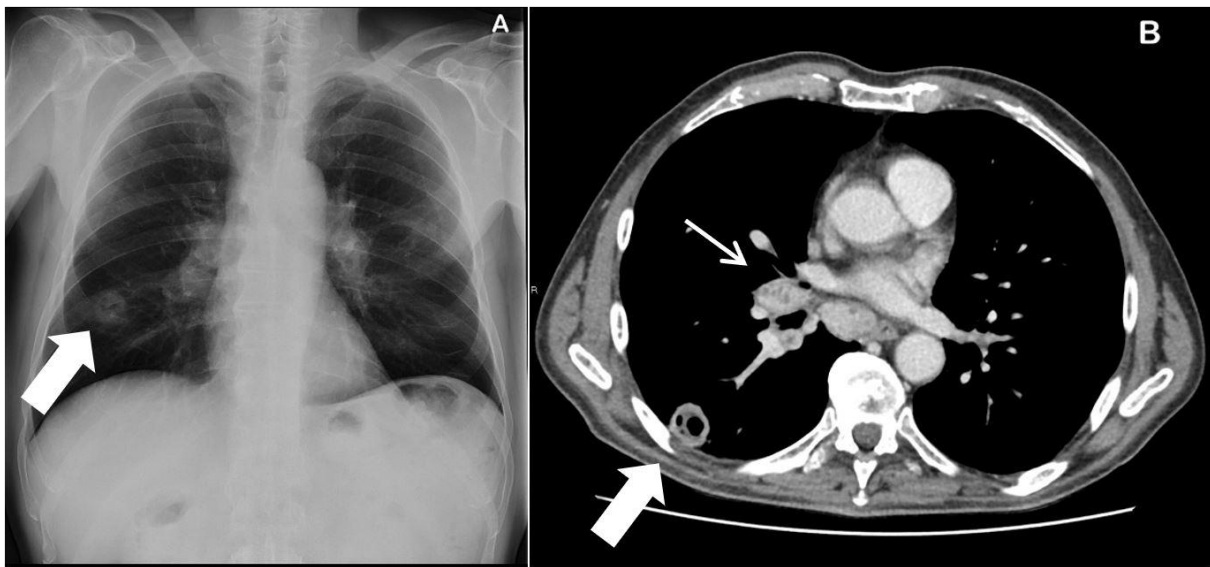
A) Chest X-ray showing a cavitory nodule (wide arrow) in the right lower lobe B) Axial CT image showing mediastinal and hilar lymph adenopathy with necrosis (narrow arrow) and a cavitory nodule in the right lower lobe (wide arrow).
